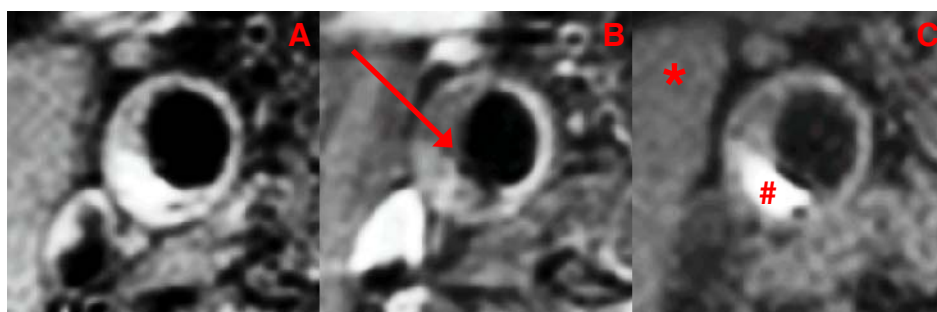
MR images showing T1w QIR TSE pre- (A) and postcontrast (B) and T1w IR-TFE (C). Note the absence of a continuous high signal between LRNC and lumen (arrow) indicating a thin or ruptured fibrous cap and the hyperintense signal (#) in the IR-TFE image compared with the sternocleidomastoid muscle (*) indicating IPH.
